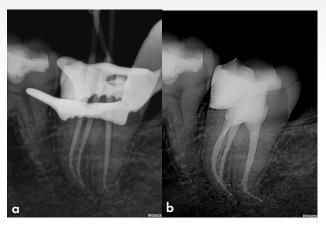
(a) Conefit periapical radiograph; (b) Final postoperative result. Note the apical lateral canals that were obturated with the AH Plus BioCeramic sealer
